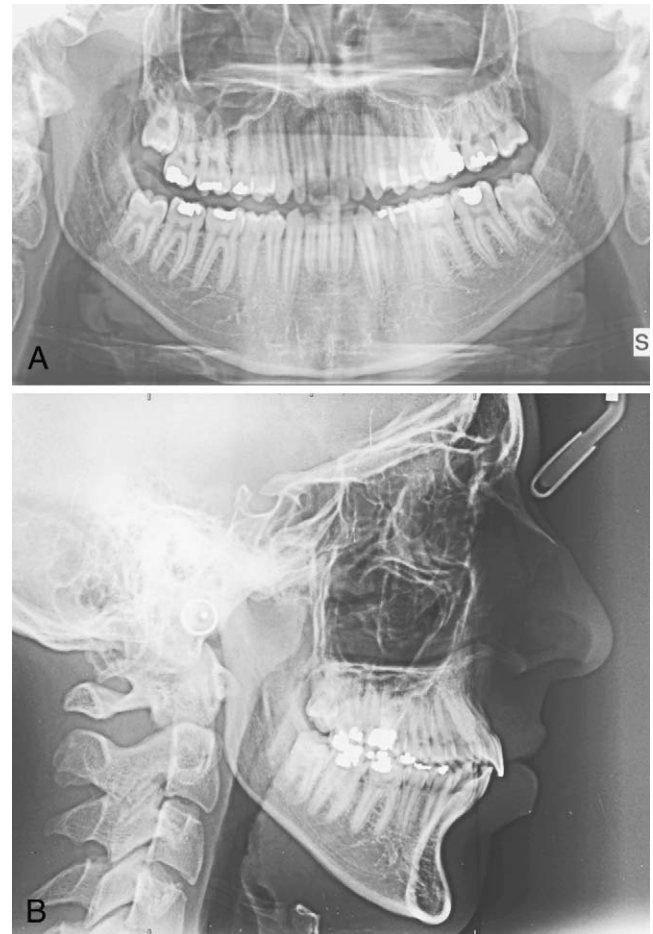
Long-term (41 months posttreatment) panoramic and cephalometric radiographs.
